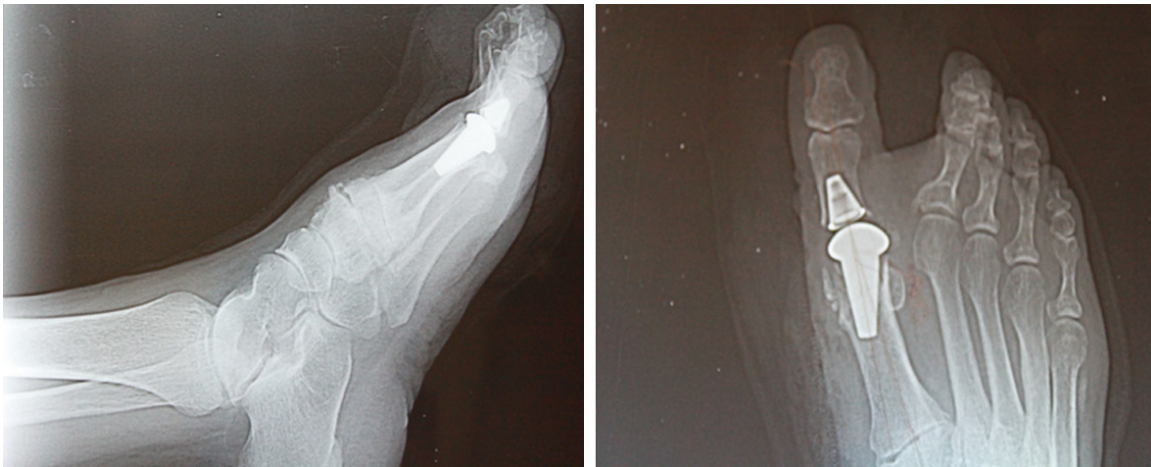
Anterior-posterior and lateral foot X-Rays on the Post-op first day; first MTP joint total arthroplasty in over-correction.
